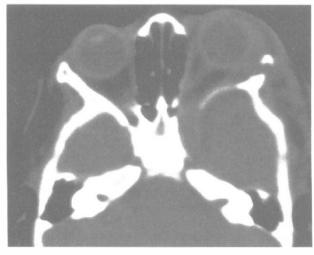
Axial CT scan of the orbits showing the hypoplastic greater wing of the sphenoid with dural ectasia and proptosis of the left eye.
